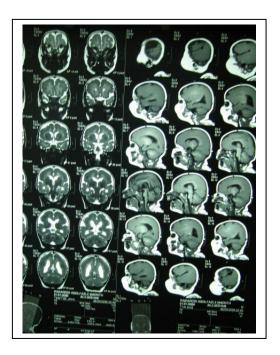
MRI of 17p13.3 microdeletion patients: the one on the left belonging to patient 20375 shows a more severe form of lissencephaly than the one on the right belonging to patient 23510.
